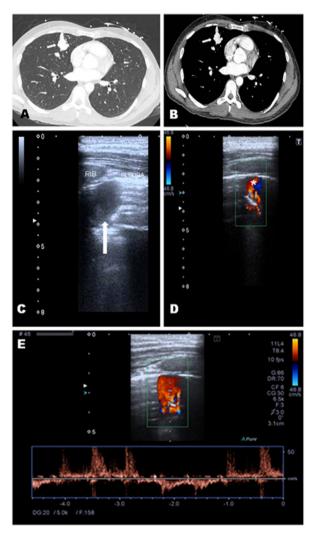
Lung CT revealed a dilated vascular structure in the right middle lobe close to the pleura (A and B, white arrow), compatible with PAVM. Pulmonary echography showed a right parasternal hypoechoic image with an intraluminal hyperechoic area, compatible with thrombosis (C, white arrow). Doppler mode revealed a 'mosaic-pattern' indicative of mixing of arterial and venous blood consistent with PAVMs (D). Here, the anterograde and retrograde flow form a "ying-yang sign" (asterisk). Pulsed doppler image demonstrated arterial and venous flows (E).
